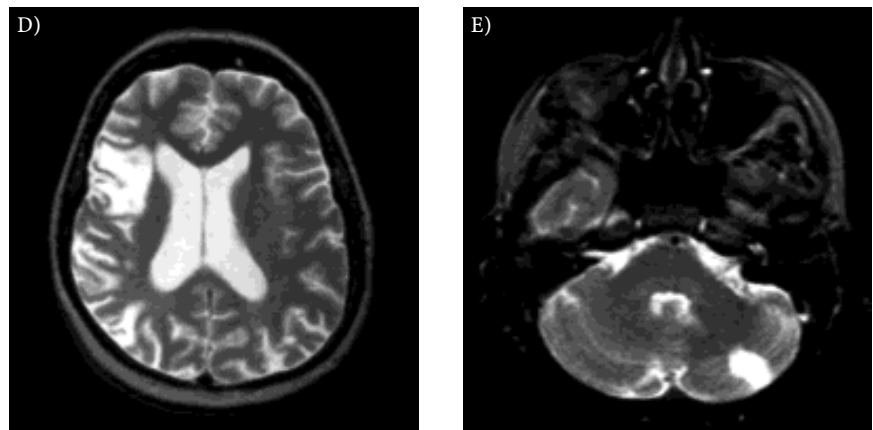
D Infarct in right parietal lobe, sulcal and ventricular enlargement on T2-weighted MRI of the brain of a 39-year-old woman with 6 years duration SLE and anticardiolipin antibodies. E 15 mm infarct at the left cerebellar hemisphere on T2-weighted MRI of the brain of a 39-year-old woman with 25 years duration of SLE and anticardiolipin antibodies
